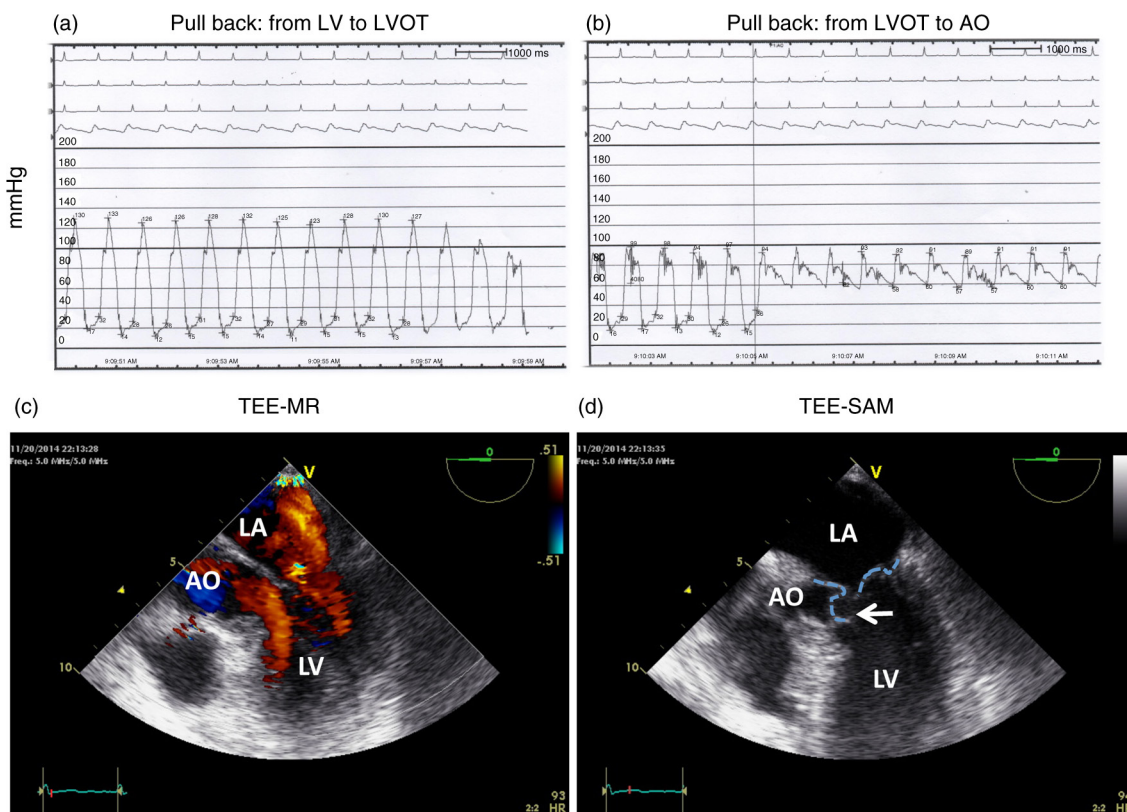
(a) Pressure tracing during pull back from left ventricle to LVOT. Notice the progressive drop of pressure. (b) Pressure tracing from LVOT to aorta. (c) TEE with color Doppler during systole. Notice the severe MR jet from LV to LA. (d) Systolic anterior motion (SAM) of the anterior mitral valve leaflet. Positions of both leaflets during systole are outlined. Arrow pointing to the anterior leaflet.
